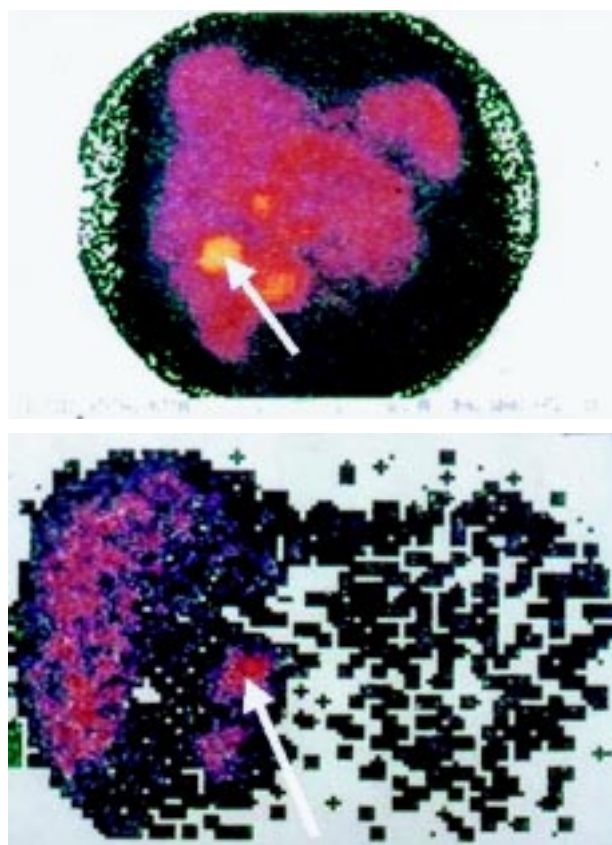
OCTREOSCAN of a patient with carcinoid tumor of the small intestine, revealing two hepatic metastatic lesions. The C/T scan and the MRI, were normal at the same time
